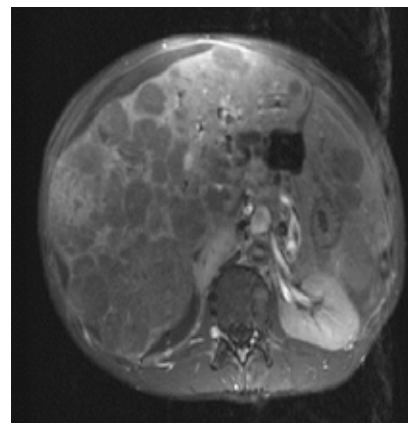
MRI of hepatoblastoma.
